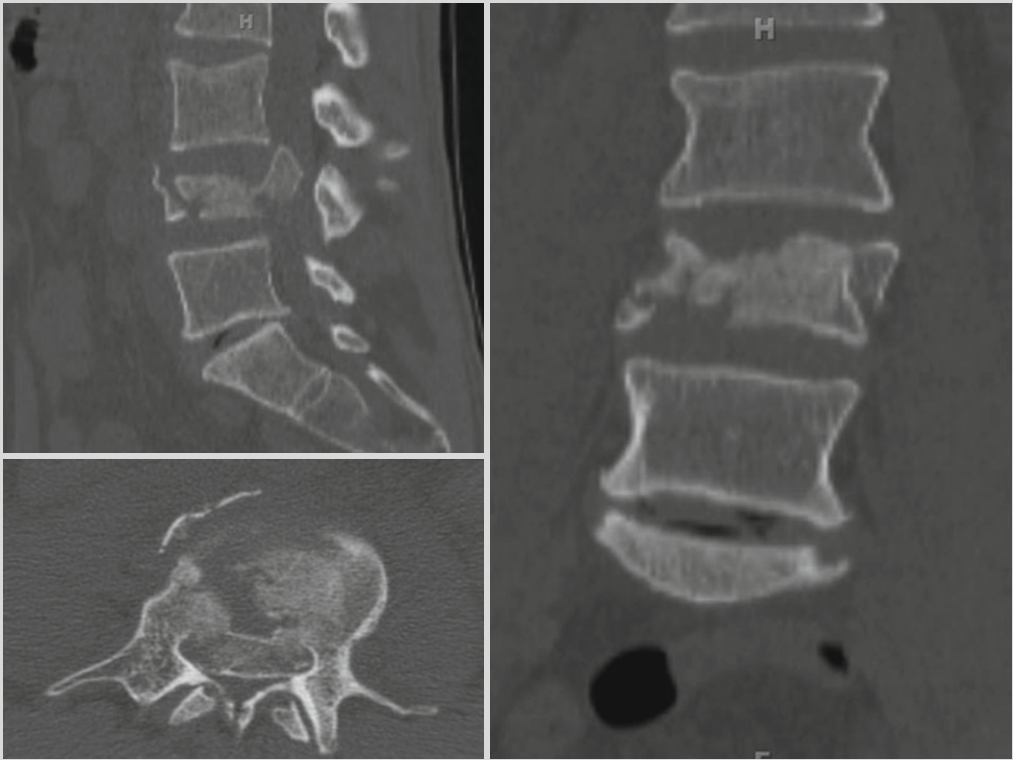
Midsagittal, coronal, and axial computed tomography (CT) images demonstrating a severe L4 burst fracture with spinal canal compromise
